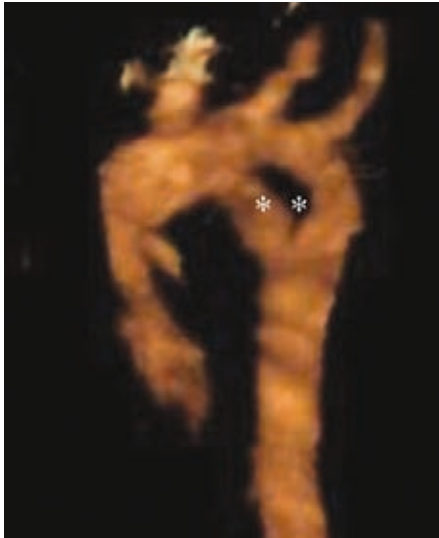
Three-dimensional reconstruction of a CT angiogram shows a double aortic arch (asterisks)
